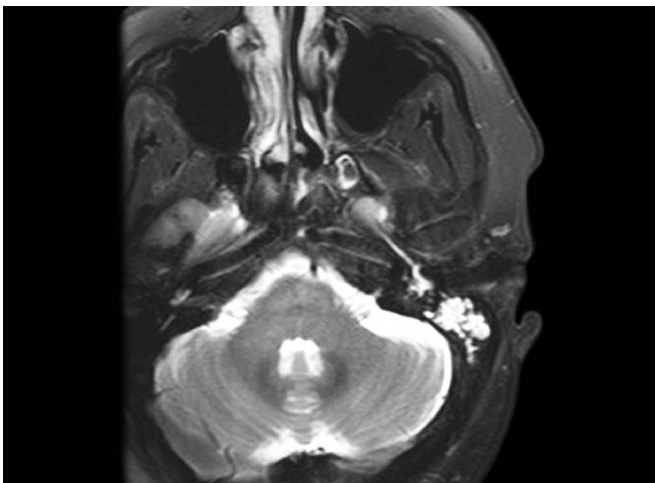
Axial, T2-weighted magnetic resonance imaging (MRI) depicting a left ear cerebrospinal fluid (CSF) leak into the mastoid and tympanic cavities. The image also captures CSF draining into the nasopharynx via the Eustachian tube.
